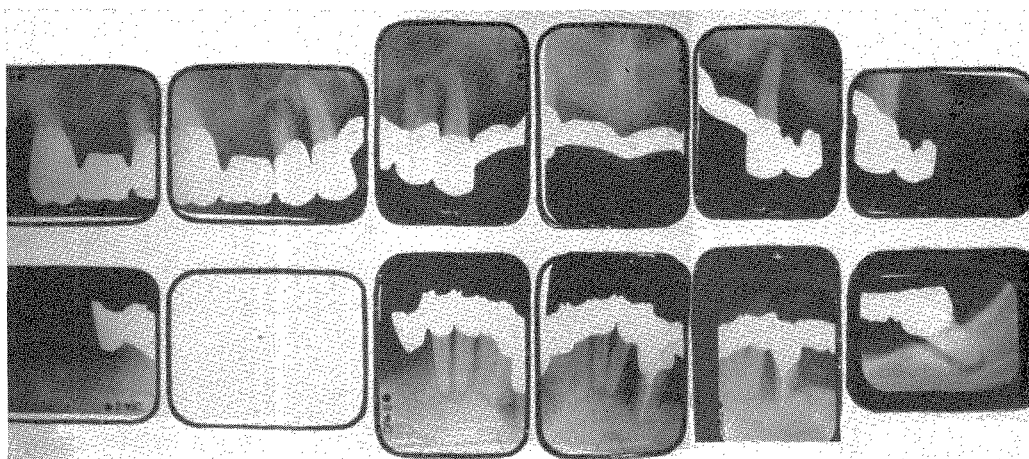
The roentgenograms which were taken in 1959. Finally the patient consented to a full upper denture but insisted upon the retention of three lower incisors.
